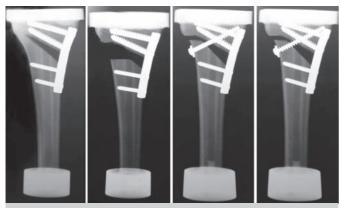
Radiographs of the models: A) cortical integrity, B) ruptured cortex (GAP), C) lateral stabilization screw with compression, D) lateral stabilization screw with compression.
